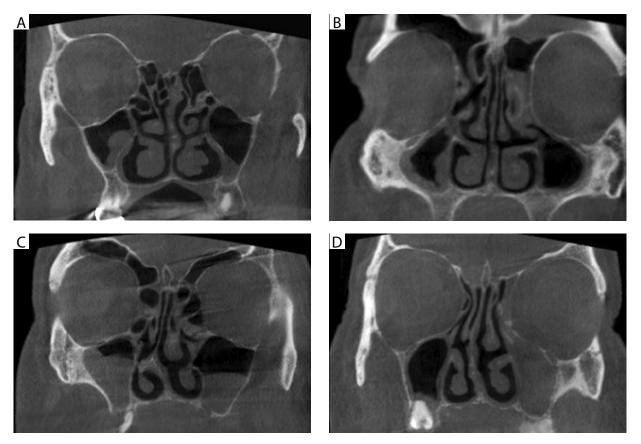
Maxillary sinus pathologies on coronal cone-beam computed tomography images. A) Ethmoid sinusitis and polypoidal mucosal thickening in the right maxillary sinus, localized mucosal thickening in the left maxillary sinus. B) Ethmoid sinusitis and generalized mucosal thickening in the right maxillary sinus. C) Ethmoid sinusitis and partial opacification in the right and left maxillary sinuses. D) Ethmoid sinusitis and total opacification in the left maxillary sinus
